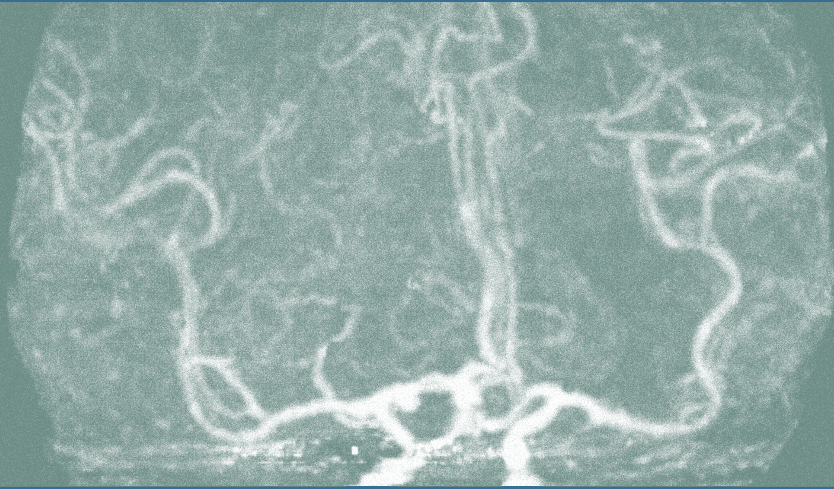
Image Processing in Vascular Computed Tomography
